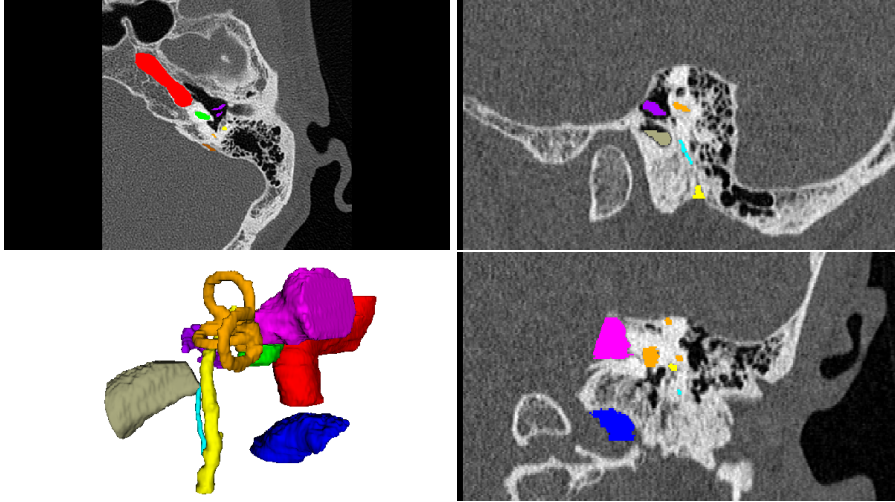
Representative CT data of the temporal bone with 3D view of risk structures.
